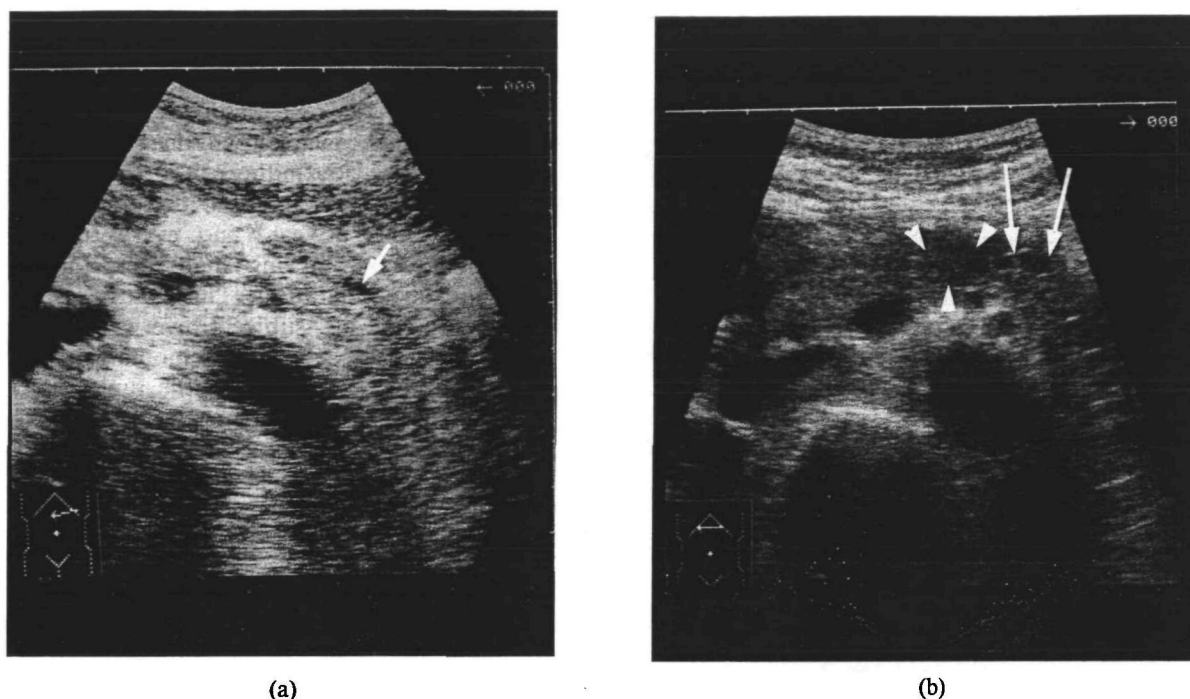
Longitudinal pancreatic sonograms of a false negative case. (a) Only slight dilatation (<2 mm) of the main pancreatic duct (arrow) is shown in the body. (b) (13 months later): A faint hypoechoic lesion 15 mm in diameter (arrow heads) with distal dilatation of the pancreatic duct (arrows) is visualized.
